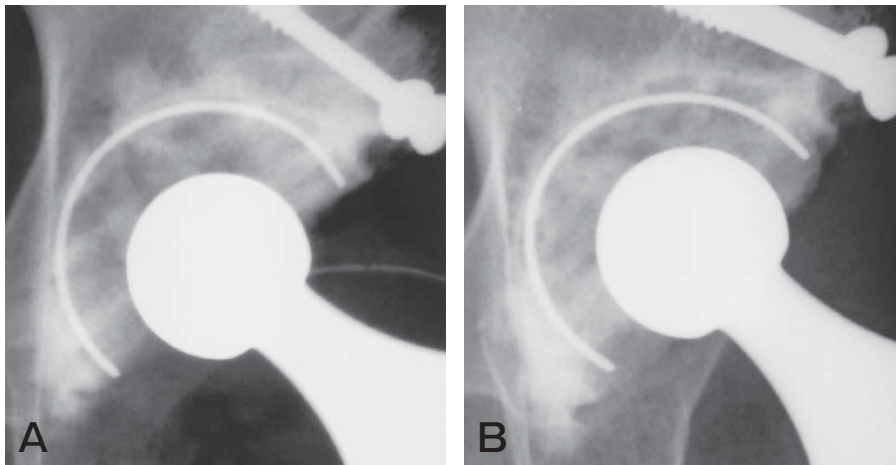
Radiographs of a 64-year-old woman who underwent THA with a bone graft and zirconia head for the right hip (OA) when she was 53 years old. No loosening was observed in the socket or the stem side at the final examination 11.2 years after operation. A, Radiographs of the socket after primary THA with bone graft; these images were taken immediately following operation; B, At 11.2 years after primary THA, the head had apparently moved to the upper side and the average annual linear wear was 0.111 mm/year.
